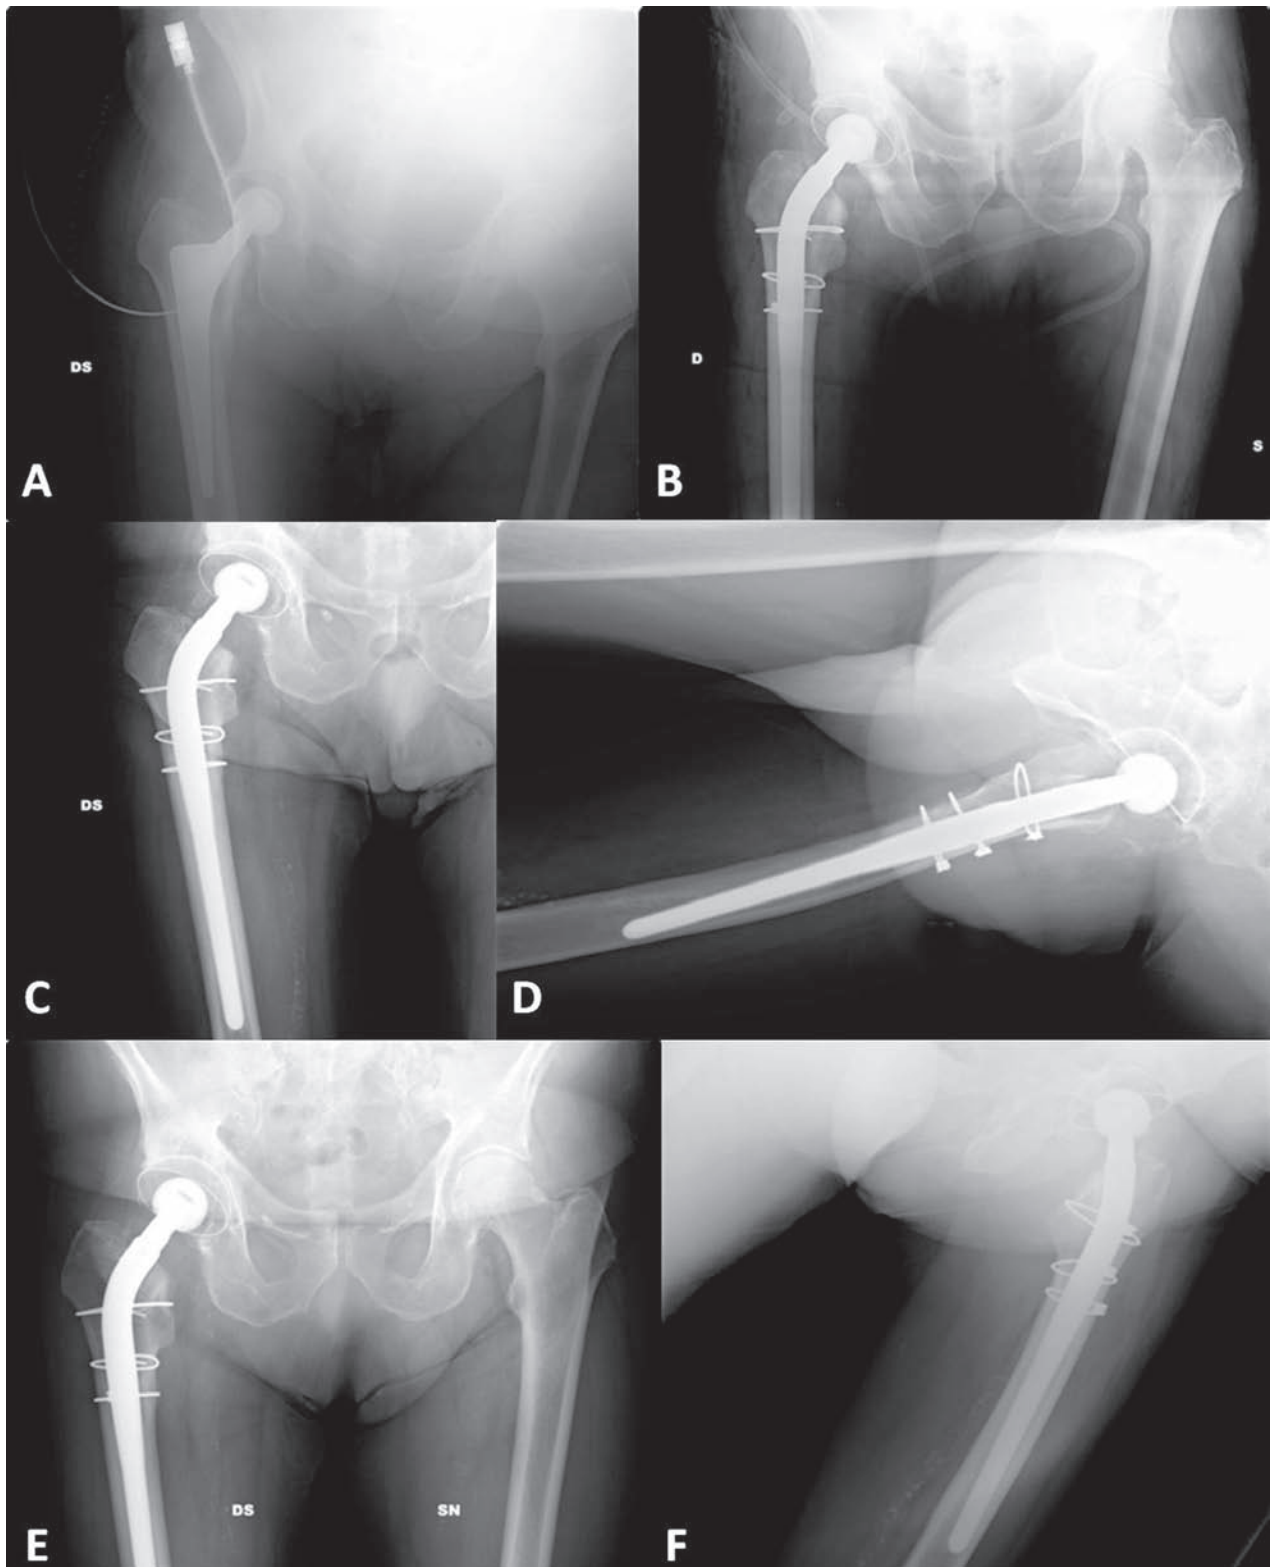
Type B2 right periprosthetic fracture. A; preoperative x-ray. B, C and D; postoperative x-ray after revision of the stem and positioning of 3 metallic cables. E and F; x-ray performed 12 months after revision with consolidation of the fracture.
